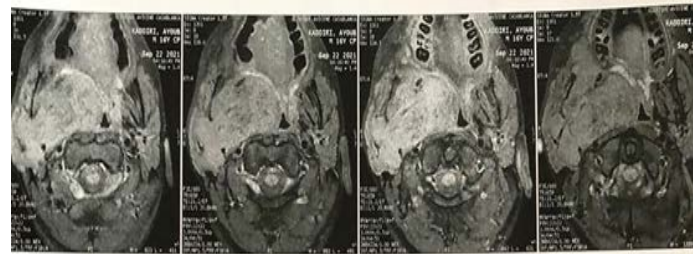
MRI on axial section showing the infiltration of the base the tongue and the hypopharynx.
